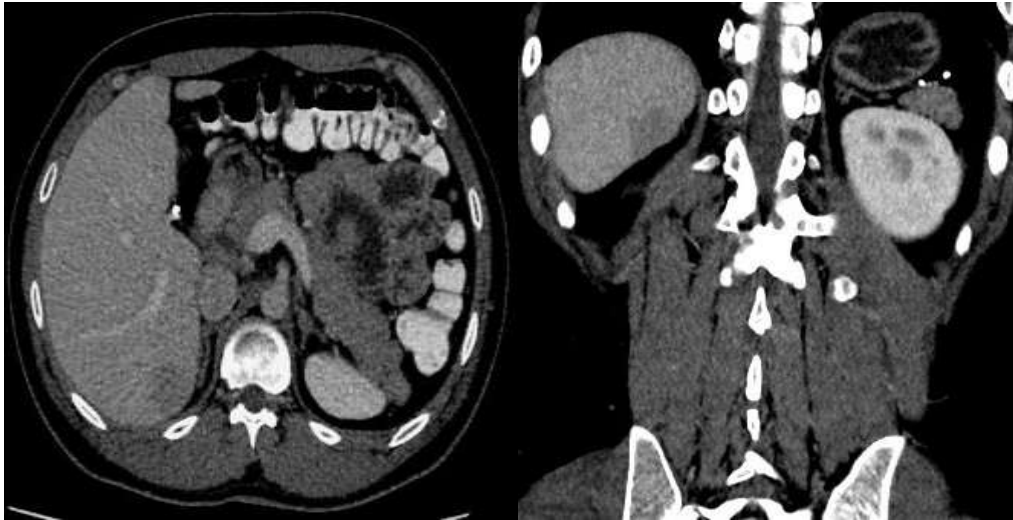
The axial contrast CT section shows well-demarcated subcapsular isodense lesion in right lobe segment VI with hypoenhancement on arterial and portal phase with no significant washout on delayed phase.
